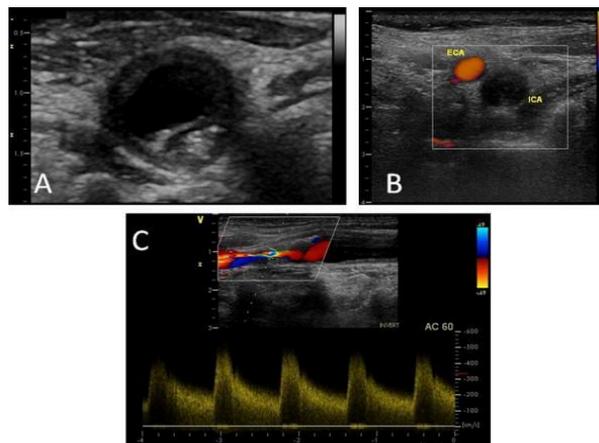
Color and Pulse-wave Doppler of stenosis of ICA
